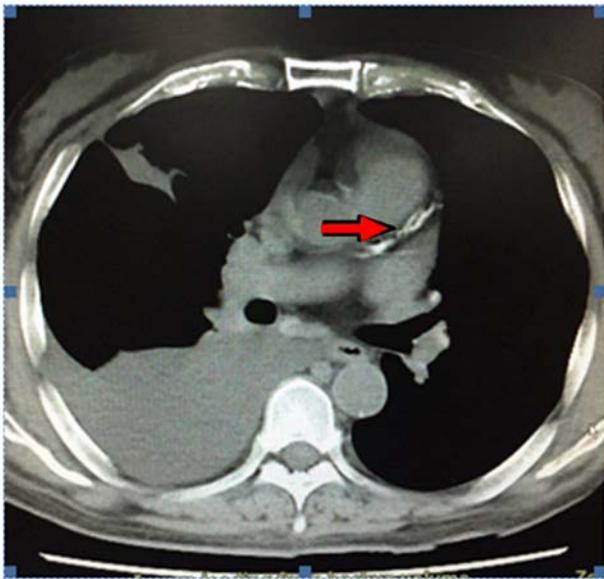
Chest CT prior to liver transplantation. After hospitalized, chest CT tested bilateral pleural effusion, cirrhosis and ascites as highlighted by the red arrow.
